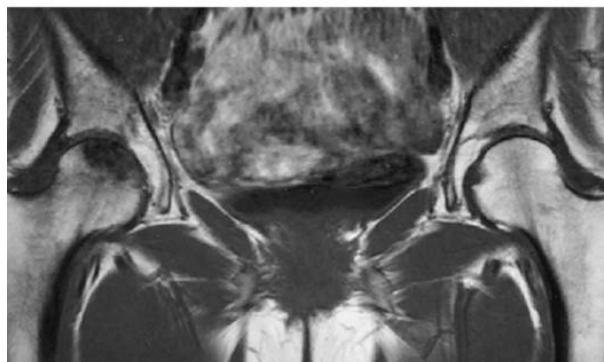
Superior sensitivity of magnetic resonance imaging (MRI) in the diagnosis of osteonecrosis of the femoral head. A 45-year-old woman receiving high-dose glucocorticoids developed right hip pain. Conventional x-rays (*top*) demonstrated only mild sclerosis of the right femoral head. T1-weighted MRI (*bottom*) demonstrated low-density signal in the right femoral head, diagnostic of osteonecrosis.
